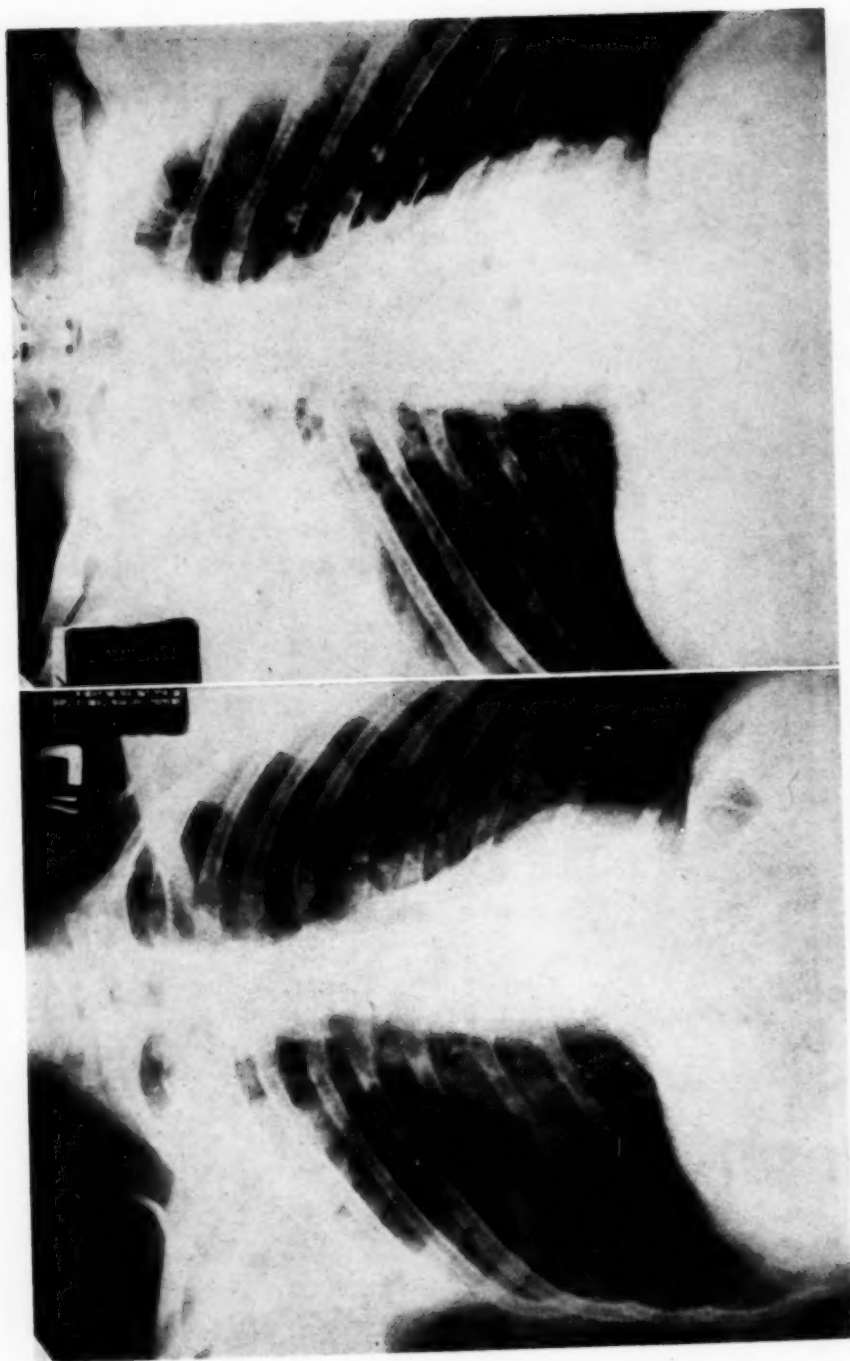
Lung abscess of six months' duration (A) which had shown no response to chemotherapy or antibiotics. Culture of the abscess at time of drainage showed the actinomycetes to be one of the predominant organisms present. (B) Roentgenogram taken six weeks following drainage.
